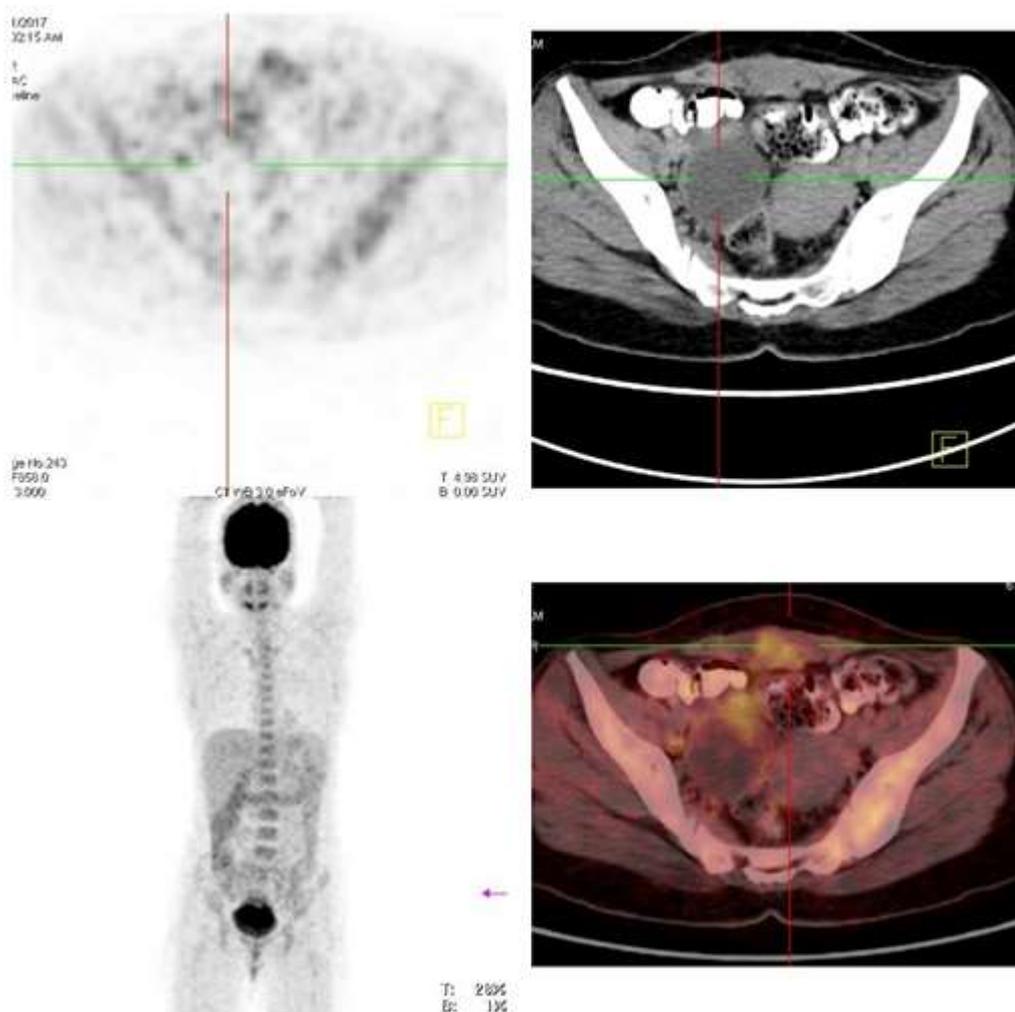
Whole Body PET SCAN images of the patient showing a urinary bladder wall tumor mass extending to uterine wall and right ovary and demonstrating an increased FDG uptake throughout the tumor. No growth or FDG uptake was noted elsewhere in the body.
